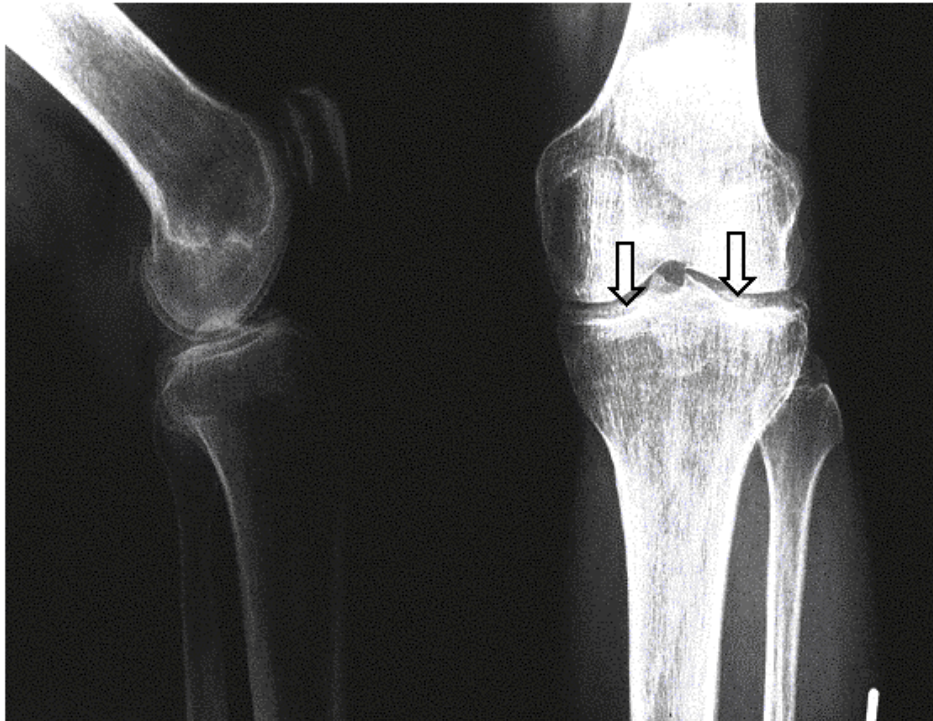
Radiography of the knee shows calcification of the menisci (arrows).
